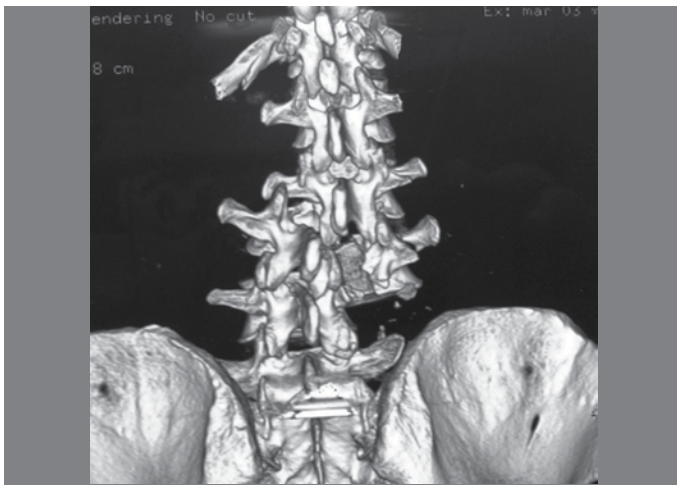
Presurgical CT.
